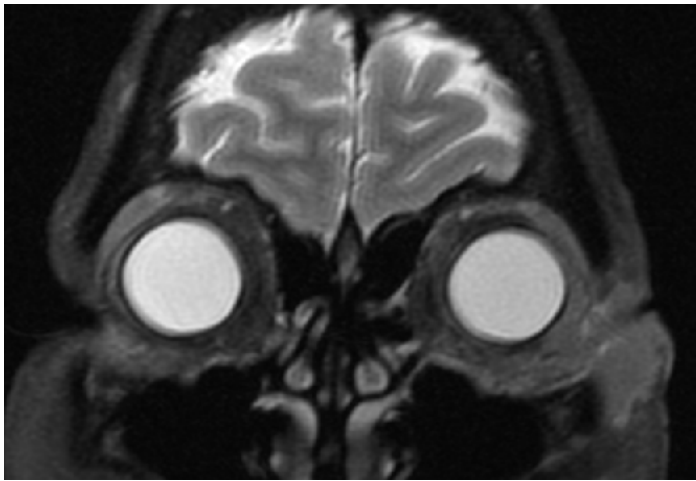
T2 MRI in a coronal section demonstrating a mass lesion in the subcutaneous region of the left cheek and lateral to the left eye that is extending into the lateral and inferior part of the left orbit
